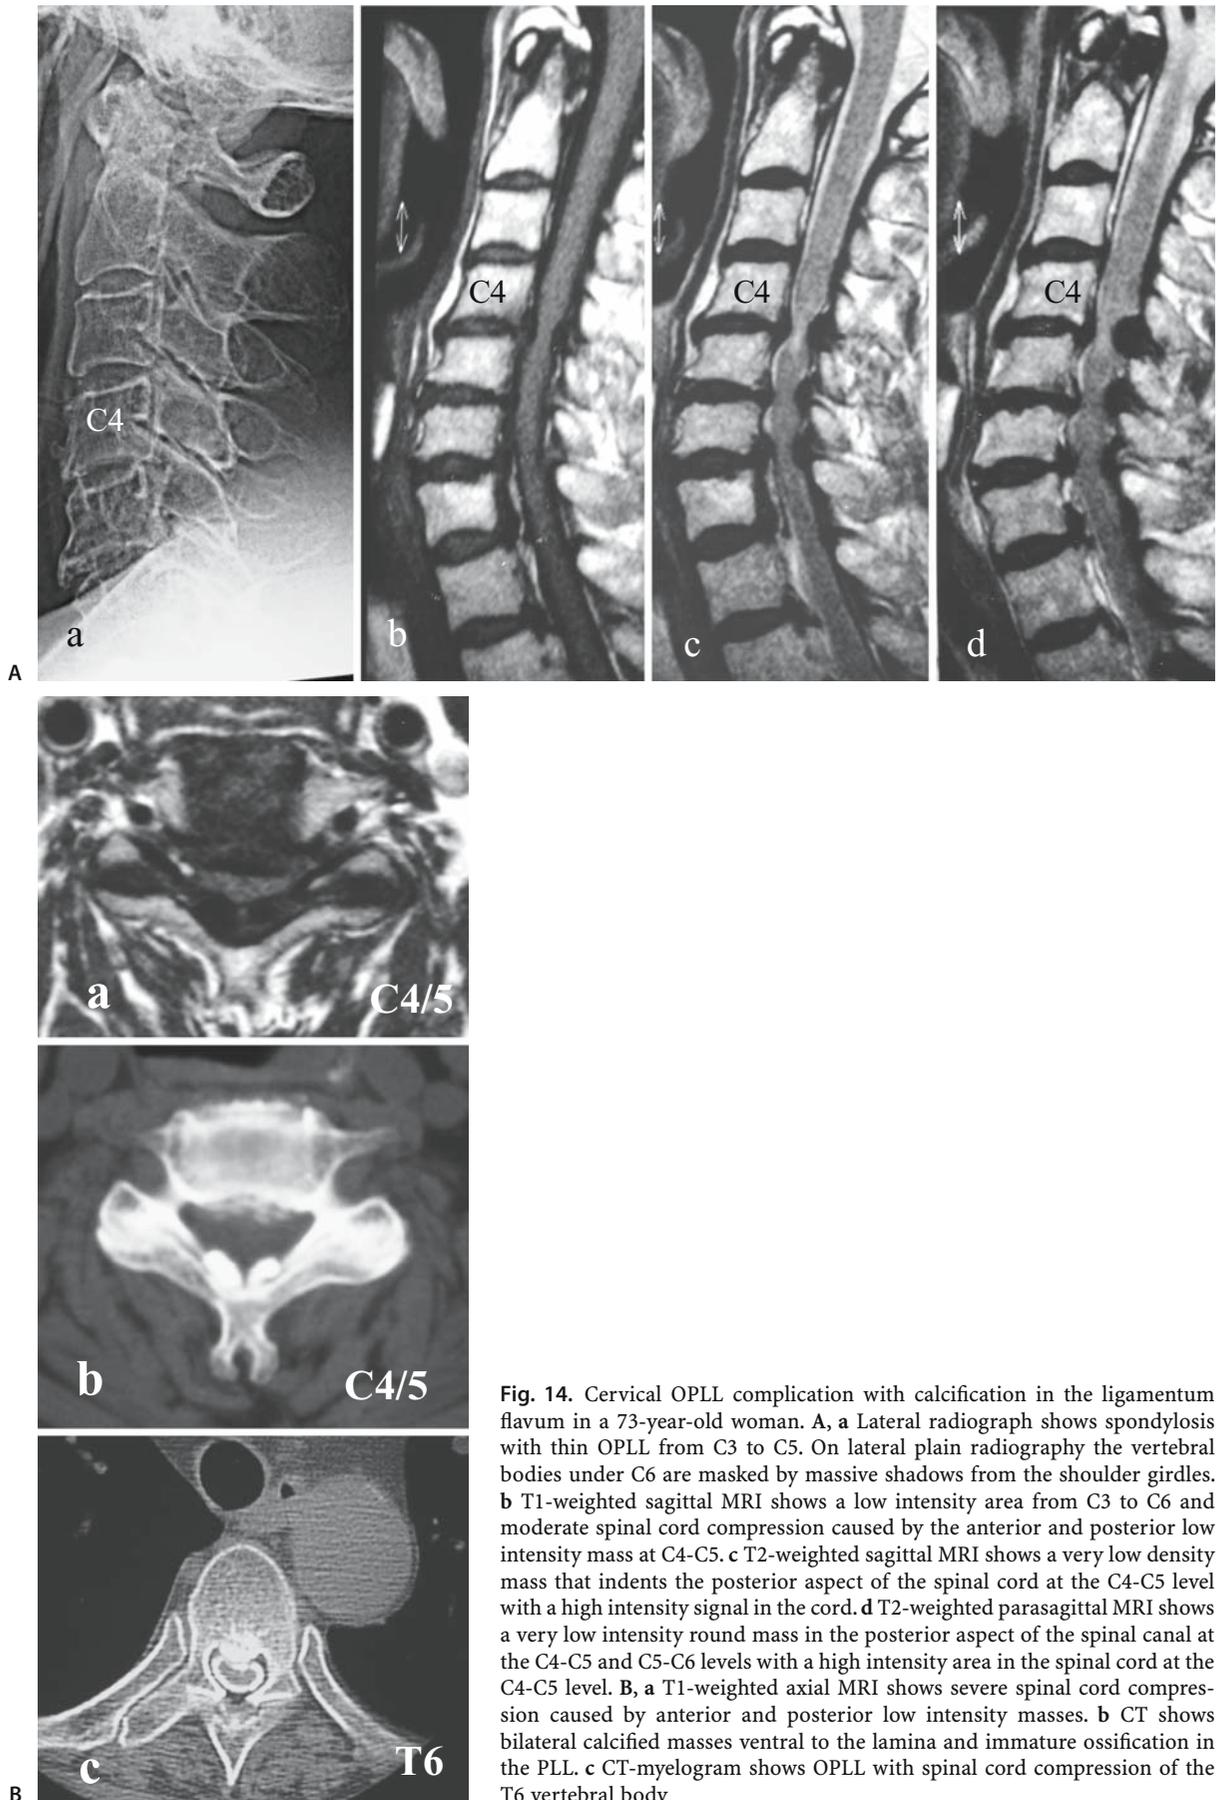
Cervical OPLL complication with calcification in the ligamentum flavum in a 73-year-old woman. A, a Lateral radiograph shows spondylosis with thin OPLL from C3 to C5. On lateral plain radiography the vertebral bodies under C6 are masked by massive shadows from the shoulder girdles. b T1-weighted sagittal MRI shows a low intensity area from C3 to C6 and moderate spinal cord compression caused by the anterior and posterior low intensity mass at C4-C5. c T2-weighted sagittal MRI shows a very low density mass that indents the posterior aspect of the spinal cord at the C4-C5 level with a high intensity signal in the cord. d T2-weighted parasagittal MRI shows a very low intensity round mass in the posterior aspect of the spinal canal at the C4-C5 and C5-C6 levels with a high intensity area in the spinal cord at the C4-C5 level. B, a T1-weighted axial MRI shows severe spinal cord compression caused by anterior and posterior low intensity masses. b CT shows bilateral calcified masses ventral to the lamina and immature ossification in the PLL. c CT-myelogram shows OPLL with spinal cord compression of the T6 vertebral body
